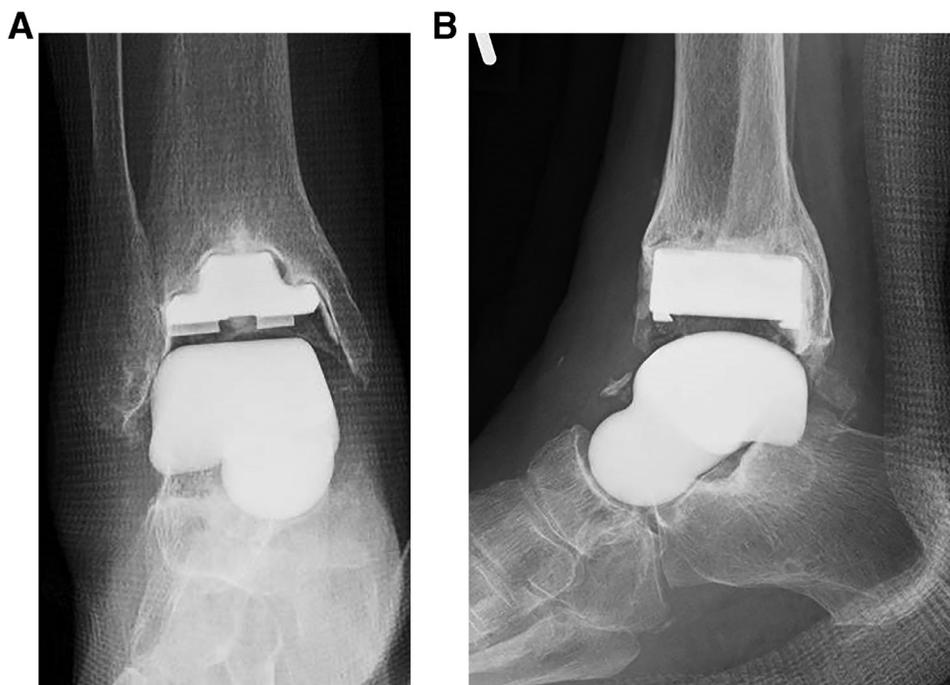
Postoperative radiographs taken after the revision total ankle arthroplasty. (A) Anteroposterior; (B) lateral. A new tibial component was fixed with cement, and the total talar prosthesis was inserted after removal of all the implants.
